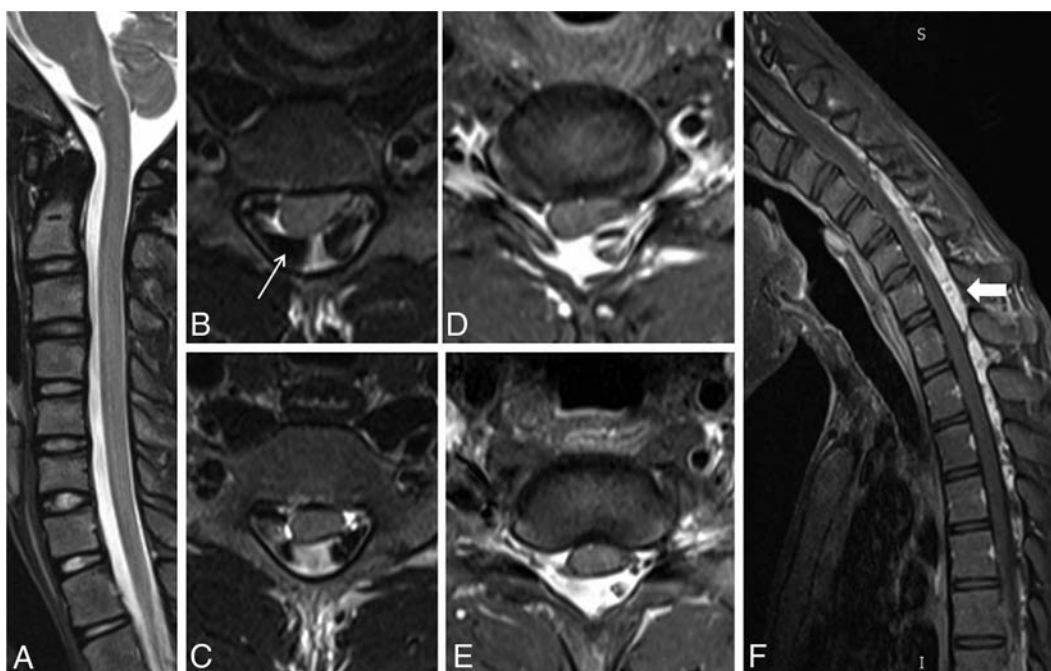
A 20-year-old male patient with weakness and wasting of the left hand muscles. Neutral position sagittal T2-weighted image (A) shows the normal appearance of the cervical cord. Axial T2-weighted flexion MR images (B and C) and postgadolinium T1 fat-suppressed images (D and E) show widening of the LDS with anterior displacement of the posterior dura and asymmetric cord atrophy, more on the left side, along with multiple flow voids within the posterior epidural space (arrow). Postgadolinium T1 fat-suppressed flexion MR sagittal image (F) shows an enhancing posterior epidural venous plexus extending from the C4 to T4 vertebral level (block arrow).
